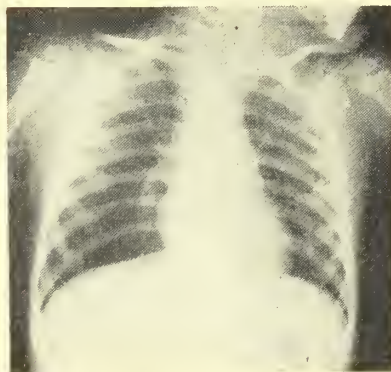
Raw carrot in right bronchus—12 hours' duration. The roentgenogram shows an early emphysema of the right lung.
